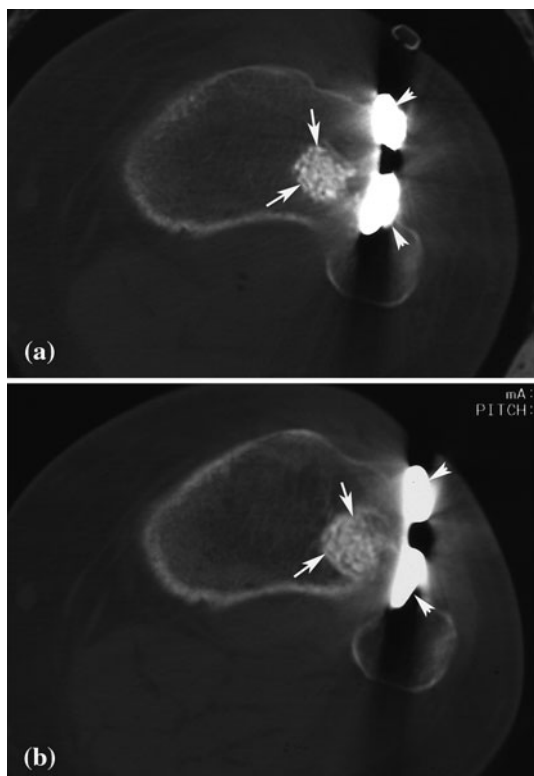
Axial CT images. Same patient postoperatively (a) and at 12 months (b). Images at the level of bioactive glass filling (arrows). Metal implant indicated with arrowheads. Blurring of the interface between glass and surrounding host bone is clearly demonstrated, as originally sharp boundaries of the glass granules become gradually smoother with time. This is supposed to demonstrate growth of new bone in between the incorporating granules
